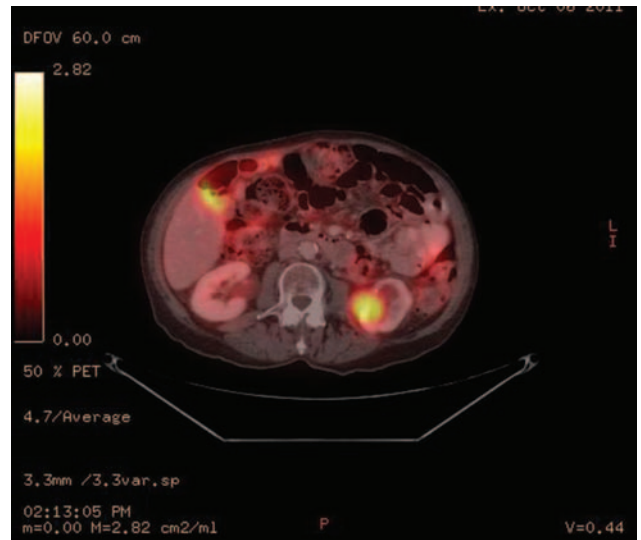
PET-CT scan with the enhancing left renal mass.
